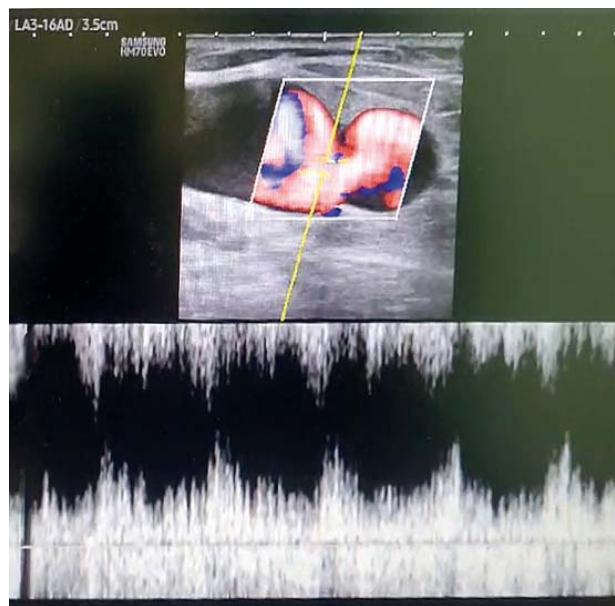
Ultrasound imaging of mixed blood flow in the arteriovenous fistula
